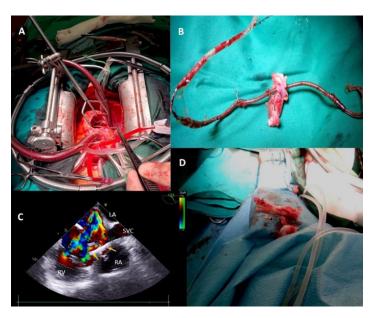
Tricuspid valve replacement, remove ventricular lead. Opened right atrium – remove ventricular lead which passes through tricuspid valve (A). Ventricular lead with a piece of septal and anterior leaflet of tricuspid valve (B). 2D TEE color Doppler. Massive tricuspid regurgitation due to damage to the valve leaflets, removed lead- yellow arrows, left atrium (LA), right atrium (RA), right ventricle (RV), superior vena cava (SVC) (C). The distal fragment of atrial lead and calcified tissues which ware around the leads (D).
